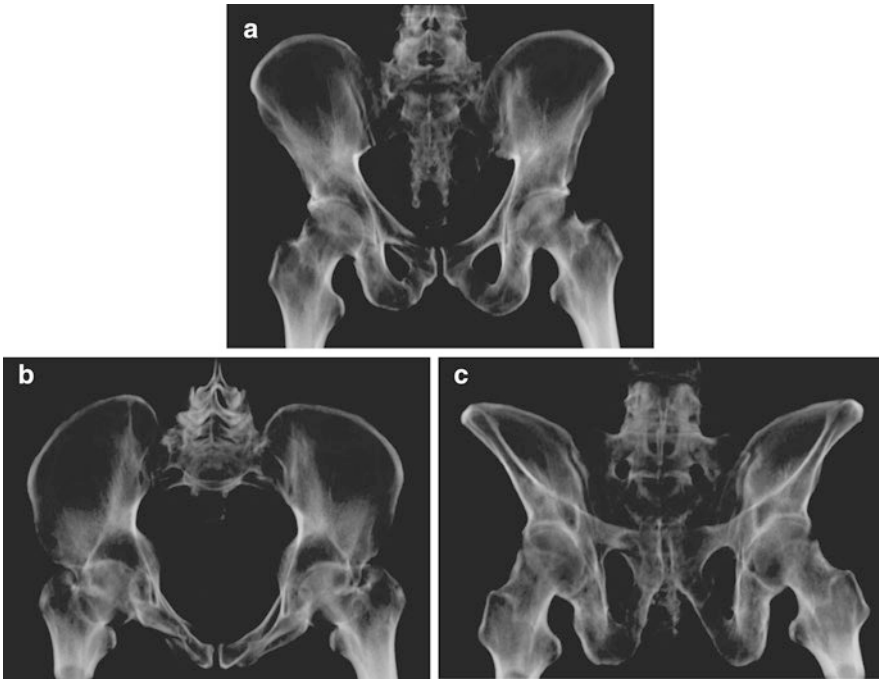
(a) AP radiograph of the pelvis. (b) Inlet radiograph of the pelvis. (c) Outlet radiograph of the pelvis
